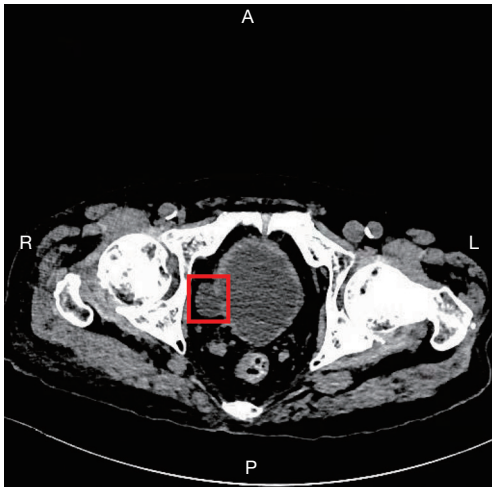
Abdominal computed tomography. Bladder diverticulum on the right side of the bladder (marked by the red square).
